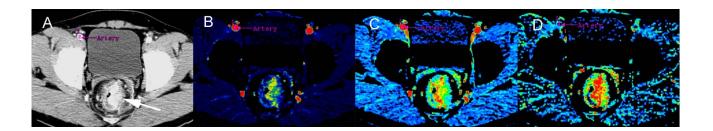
Rectal cancer (A, arrow) showing heterogeneous tumour perfusion (B), blood volume (C) & permeability(D) on the parametric maps derived from kinetic analysis of the Perfusion CT data
